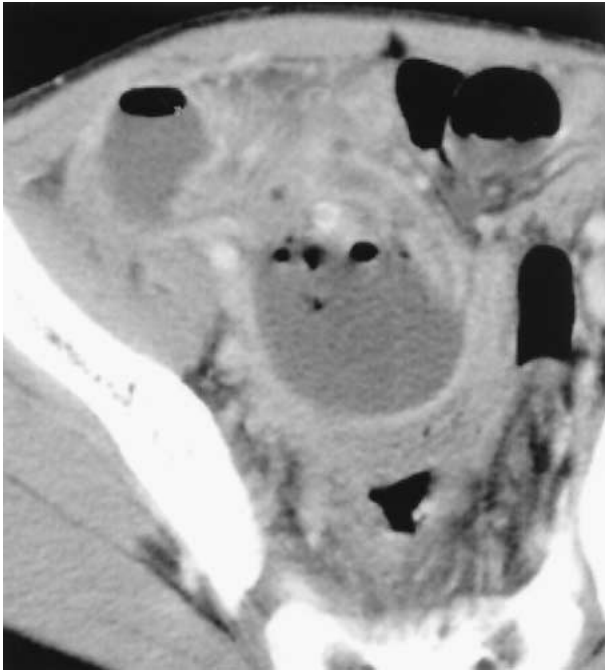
Contrast-enhanced CT image of perforated appendicitis. A large abscess containing gas bubbles is observed at the periappendiceal region. The appendix itself is not identified.
